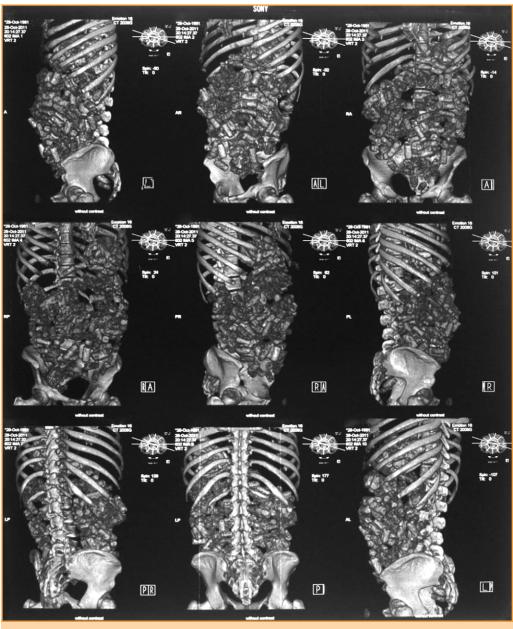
CT 3D reconstruction of the abdomen and pelvis showed numerous packets of opium in the entire gastrointestinal system.
